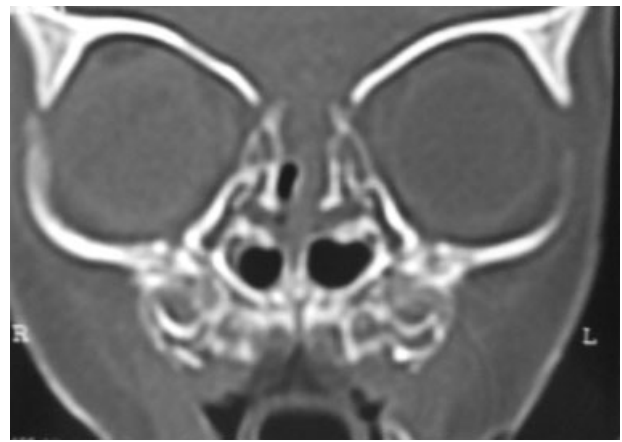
Coronal CT of a neonate with bilateral choanal atresia with soft tissue density in nasal cavity appeared continuous with brain parenchyma due to lack of ossification along the floor of the anterior cranial fossa, falsely appearing as a bony defect.
